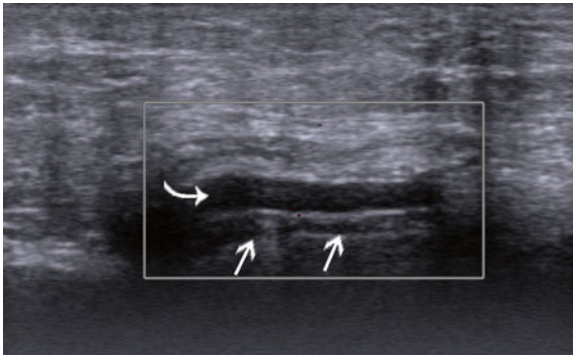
The flat mesh (*white arrows*) shown on this Doppler US is hardly conspicuous, and would be even less so if not for the small fluid collection (*curved white arrow*) overlying it.
